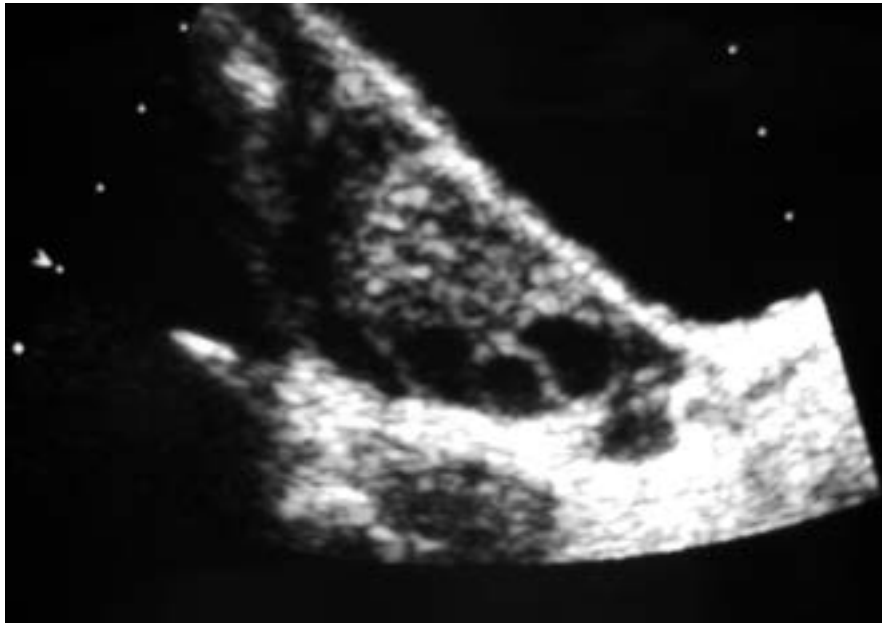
A longitudinal transabdominal ultrasound of an ovary showing multiple peripheral follicles (3).
